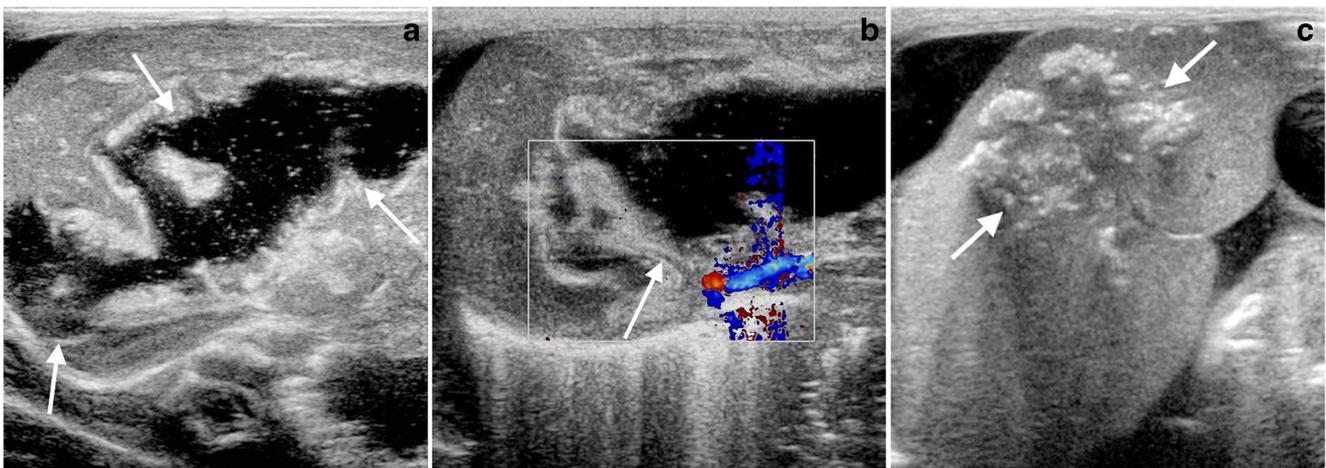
Parenteral nutrition extravasation in a 25-week-gestation premature boy. a Transverse ultrasound image at 12 days old shows a large collection within the liver parenchyma (*arrows*). b Transverse colour Doppler image of the right lobe of the liver shows that the right
